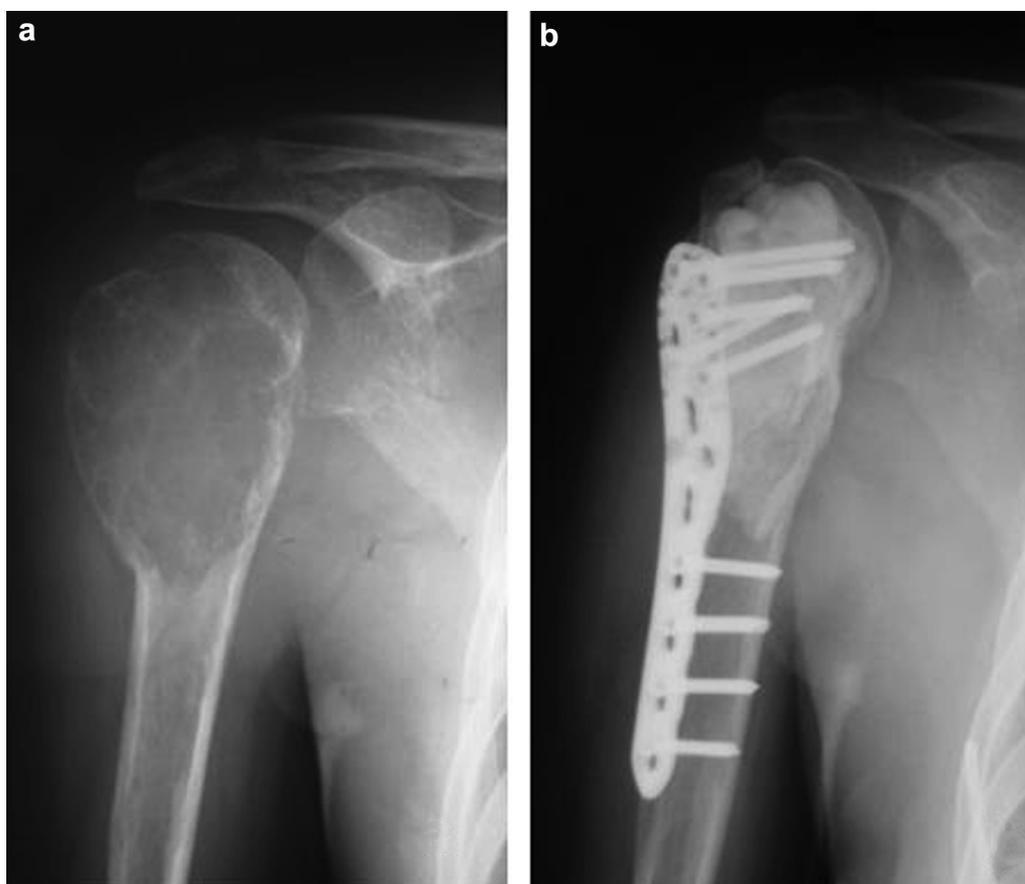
Right-sided Campanacci grade III proximal humerus giant cell tumor in a 22-year-old woman (case 9 in [Table I](#)). (a) A preoperative radiograph shows no fracture displacement. (b) A postoperative radiograph shows that the bone cement and internal fixation are in good position.
